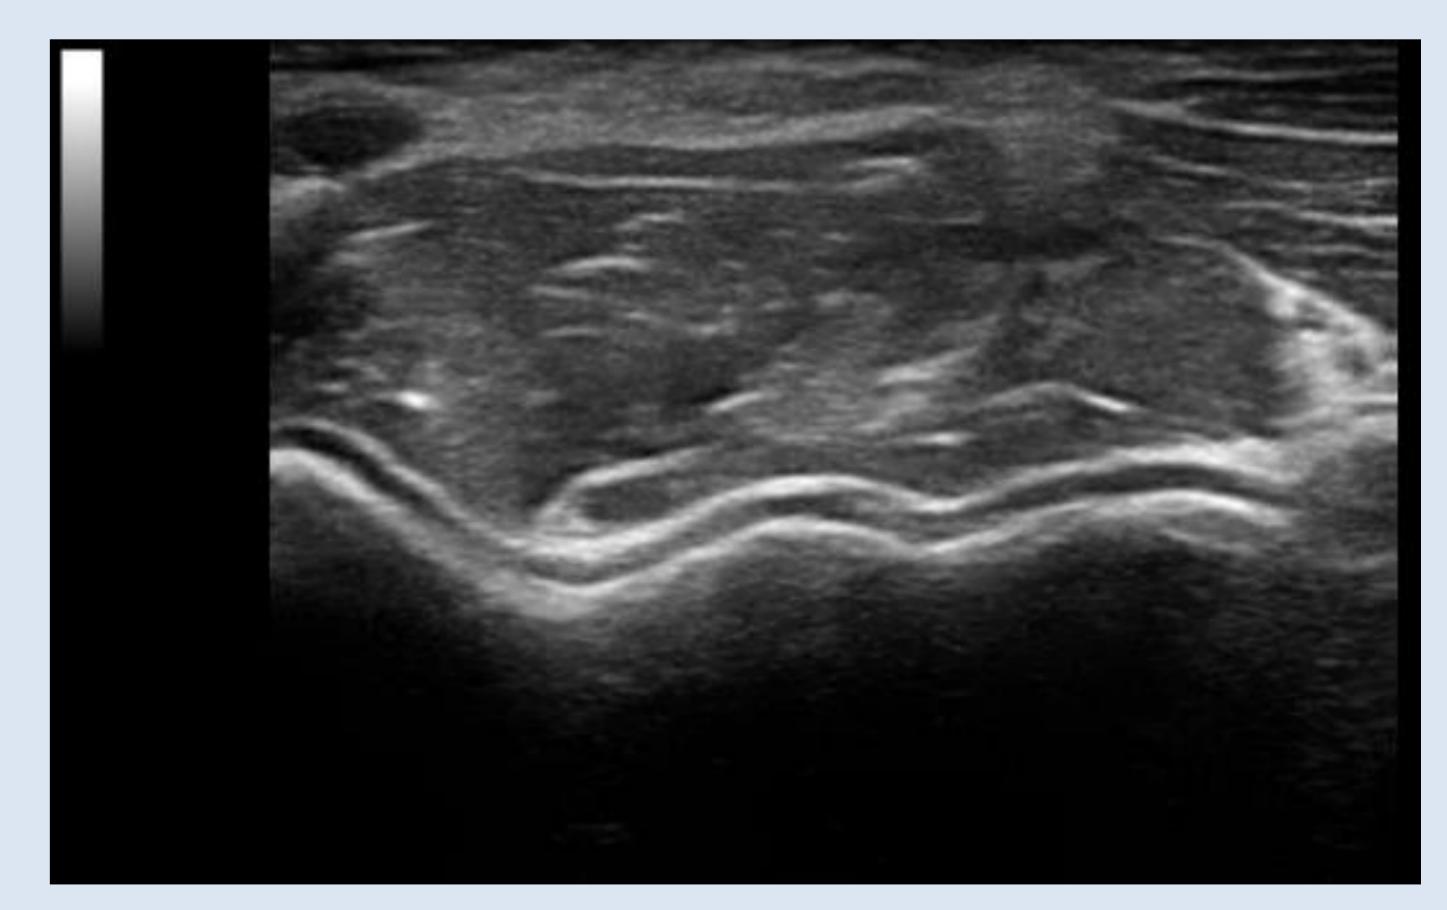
Cartilage damage of the distal humeral epiphysis of the right elbow on ultrasound. No abnormalities were found during physical examination (HJHS at joint level=0).
